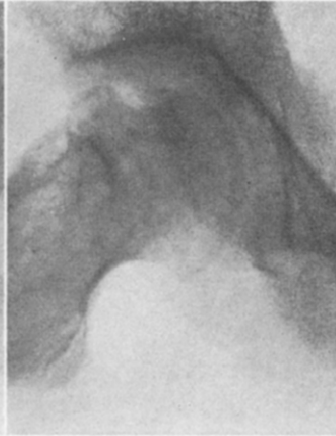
Case xx. Roentgenogram July 6, 1938; good union; primary focus in head found.
